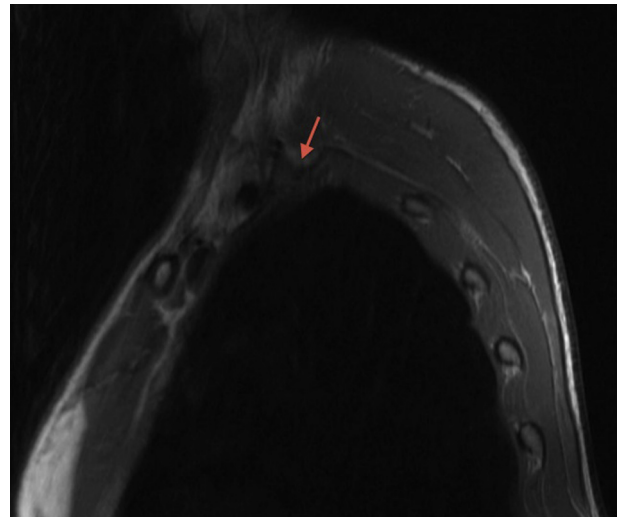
Sagittal MRI section indicating synostosis between the first and second thoracic ribs (arrow).
